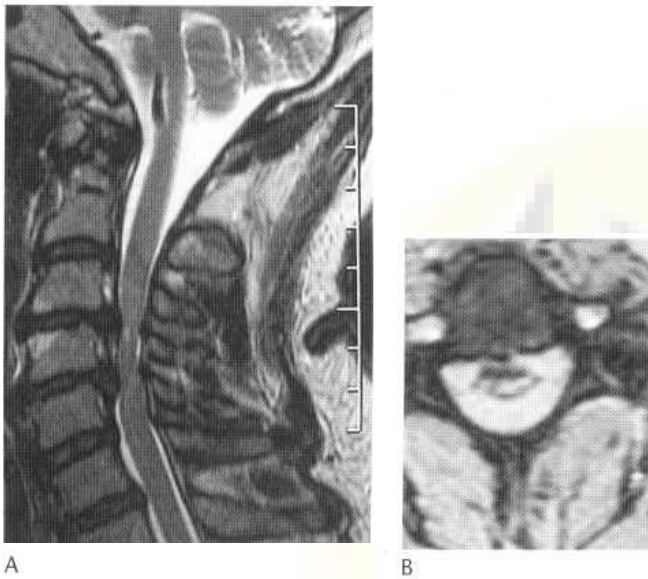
Ossification of the posterior longitudinal ligament. Sagittal (A) and axial (B) MRI with T_2 -weighted contrast. The axial image is between the intervertebral discs and shows the large low-signal thickened ligament looking somewhat like a mushroom.
